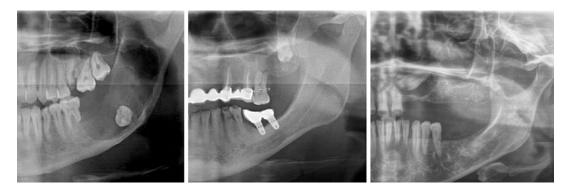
Dentigerous Cysts of three different cases. A: OPG reveals a unilocular radiolucent lesion with welldefined borders attached to the molar tooth's crown. The lesion extends from the left coronoid process of the mandible to the mandibular left molar site. B: OPG reveals a unilocular radiolucent lesion with well-defined borders attached to the cementoenamel junction of a vertical impacted molar tooth. C: OPG reveals a unilocular radiolucent lesion with well-defined borders which seem like surrounding the whole teeth. Circumferential type dentigerous cysts appear as they contain within although they are also attached to the cementoenamel junction of a tooth. CBCT is useful while evaluating lesions with relevant radiographic features
